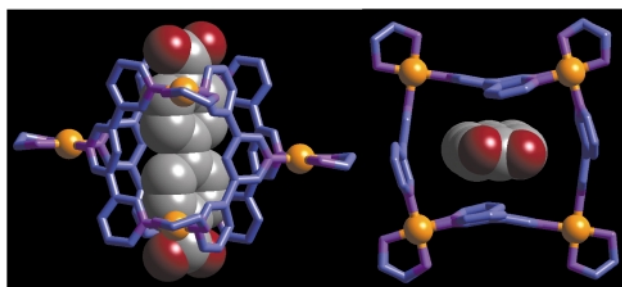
The X-ray structure of 29, side view (left) and top view (right).
